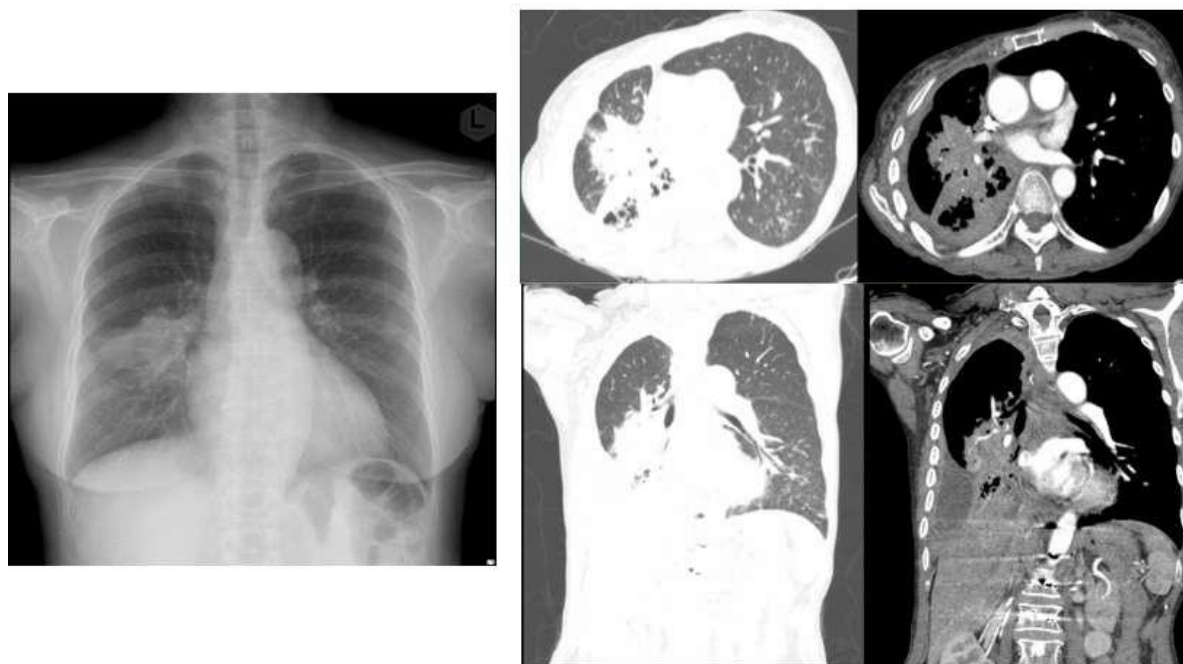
Chest radiograph (PA) and contrast-enhanced CT of the thorax demonstrate a large spiculated mass in the right middle lobe, accompanied by a right-sided pleural effusion
